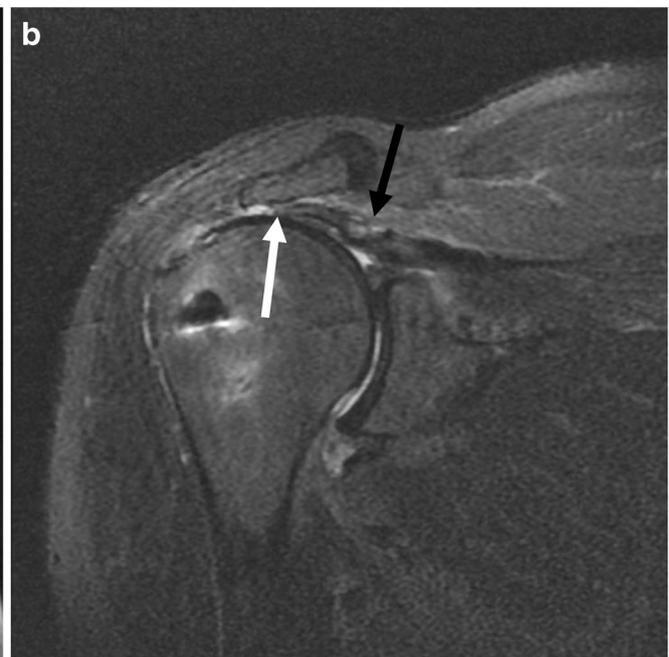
Coronal oblique T2-weighted fat-saturated image with medial failure at the graft–bone interface following superior capsular reconstruction. The medial aspect of the graft (*white arrow*) is no longer continuous with the superior aspect of the glenoid, whereas graft is seen coursing laterally (*gray arrow*) to the rotator cuff footprint
